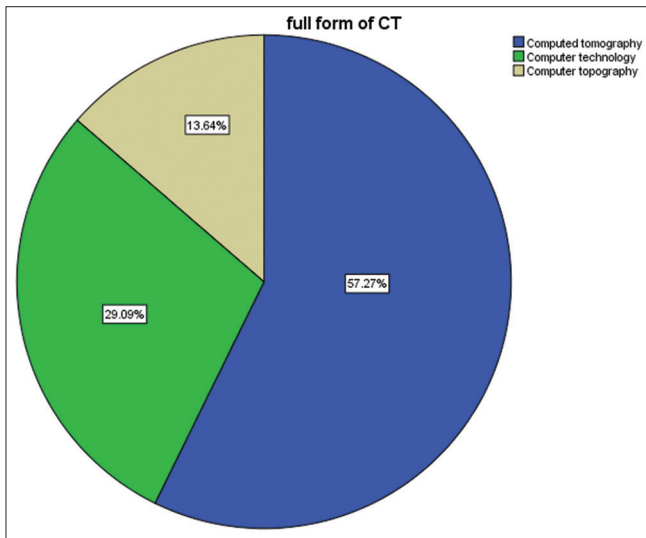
The computed tomography abbreviation responded by students
